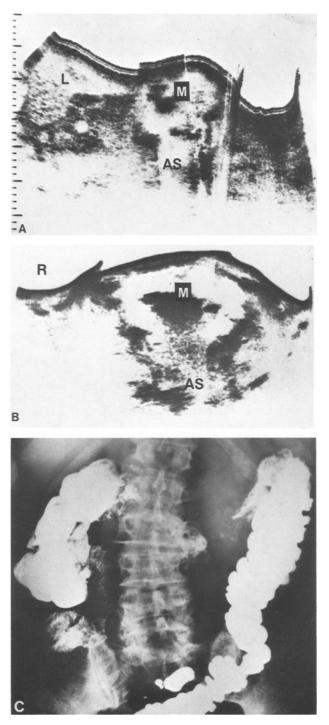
Case 1. Adenocarcinoma of the colon. A Longitudinal and B transverse sonograms showing a mass (M)  $6 \times 7 \times 8$  cm with a dark echogenic area centrally. (L liver; AS acoustic shadowing C Delayed film following barium meal showing a constricting lesion with a surrounding soft tissue mass in the transverse colon
